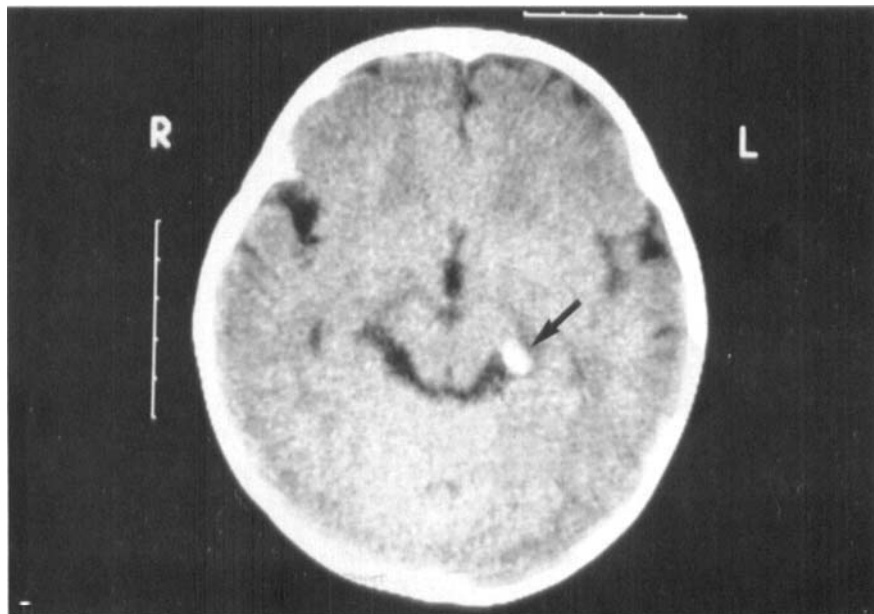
Axial non-contrast CT showing a focal hyperdensity in the region of the Left Ambient Cistern with attenuation value of 50 HU (arrow), at the site of the aneurysm.
